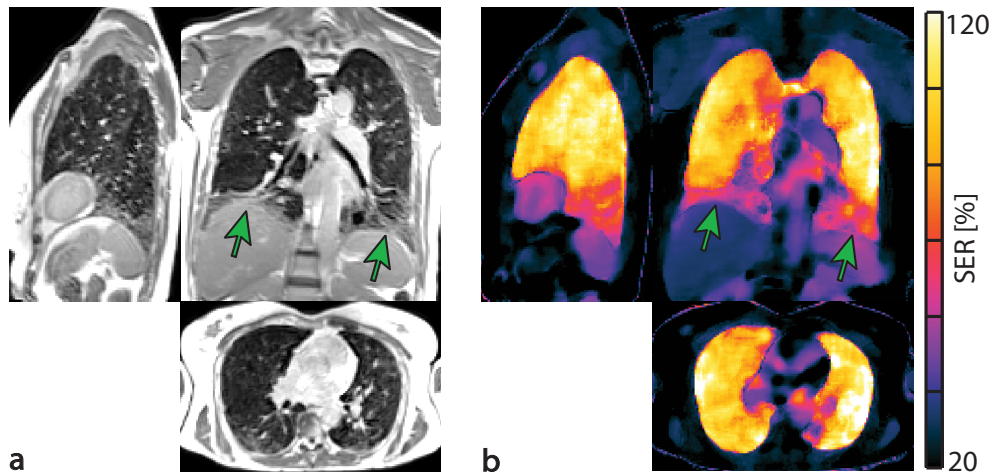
Post-contrast ufSSFP images (a), and ufSSFP-SER images (b) in a 58-year-old female patient with scleroderma and NSIP. A streaky decrease in SER is noted in both lower lobes corresponding to fibrotic changes seen on morphological MRI (green arrows).
